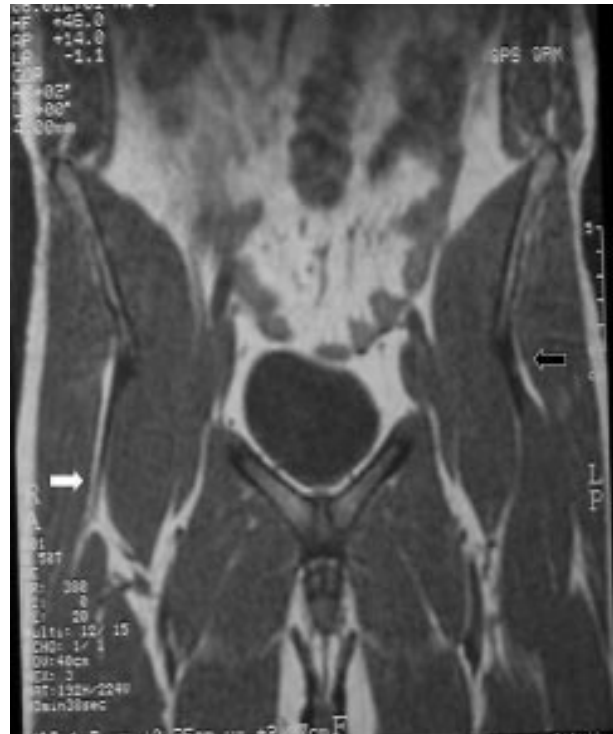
Magnetic resonance image of the thigh showing a normal rectus femoris tendon and muscle on the left (white arrow) and the proximal muscle avulsion on the right (black arrow) with a normal tendon still attached to the anterior inferior iliac spine and a very distally retracted muscle belly.
